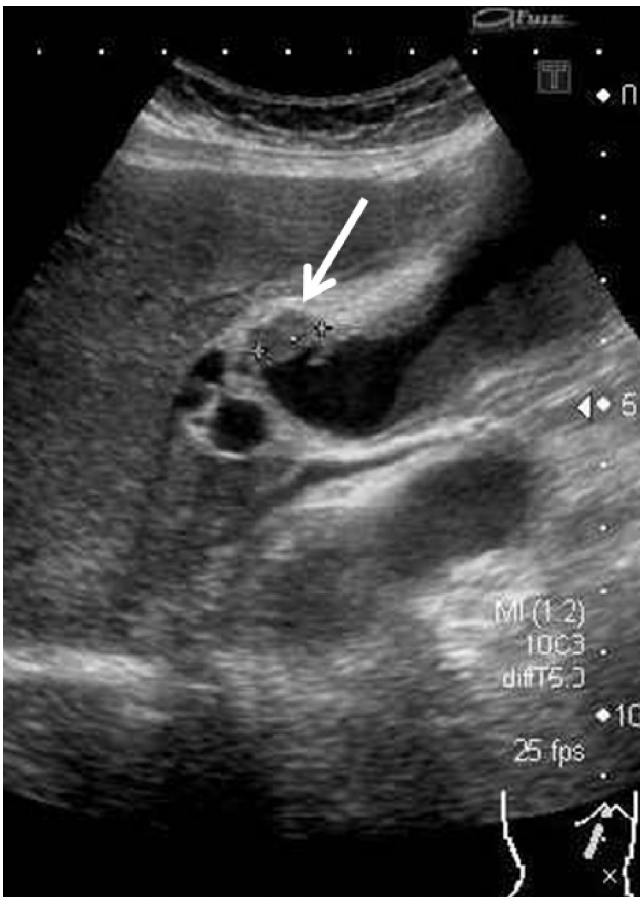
Ultrasonography also showed a tumor of 10 mm in diameter in the cystic duct.
